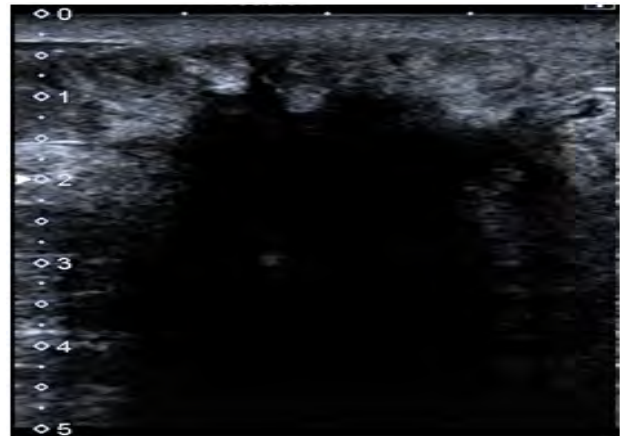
Pregnancy-associated breast cancer in a 38year old lactating woman, 10 months postpartum presented with a palpable mass in her right breast for the prior 2 months. Ultrasonography showed a hypoechoic mass at 10 o' clock position in right breast having irregular infiltrative margins and dense posterior acoustic shadowing. Core needle biopsy revealed invasive ductal carcinoma.
